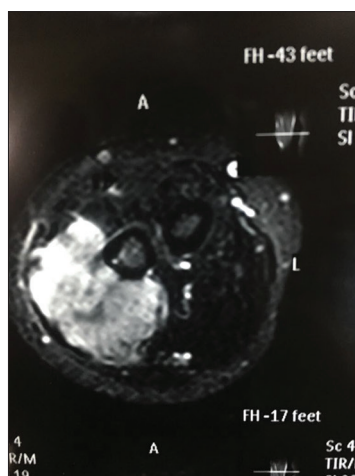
The magnetic resonance imaging of the soft-tissue tumor present in the intermuscular compartment
